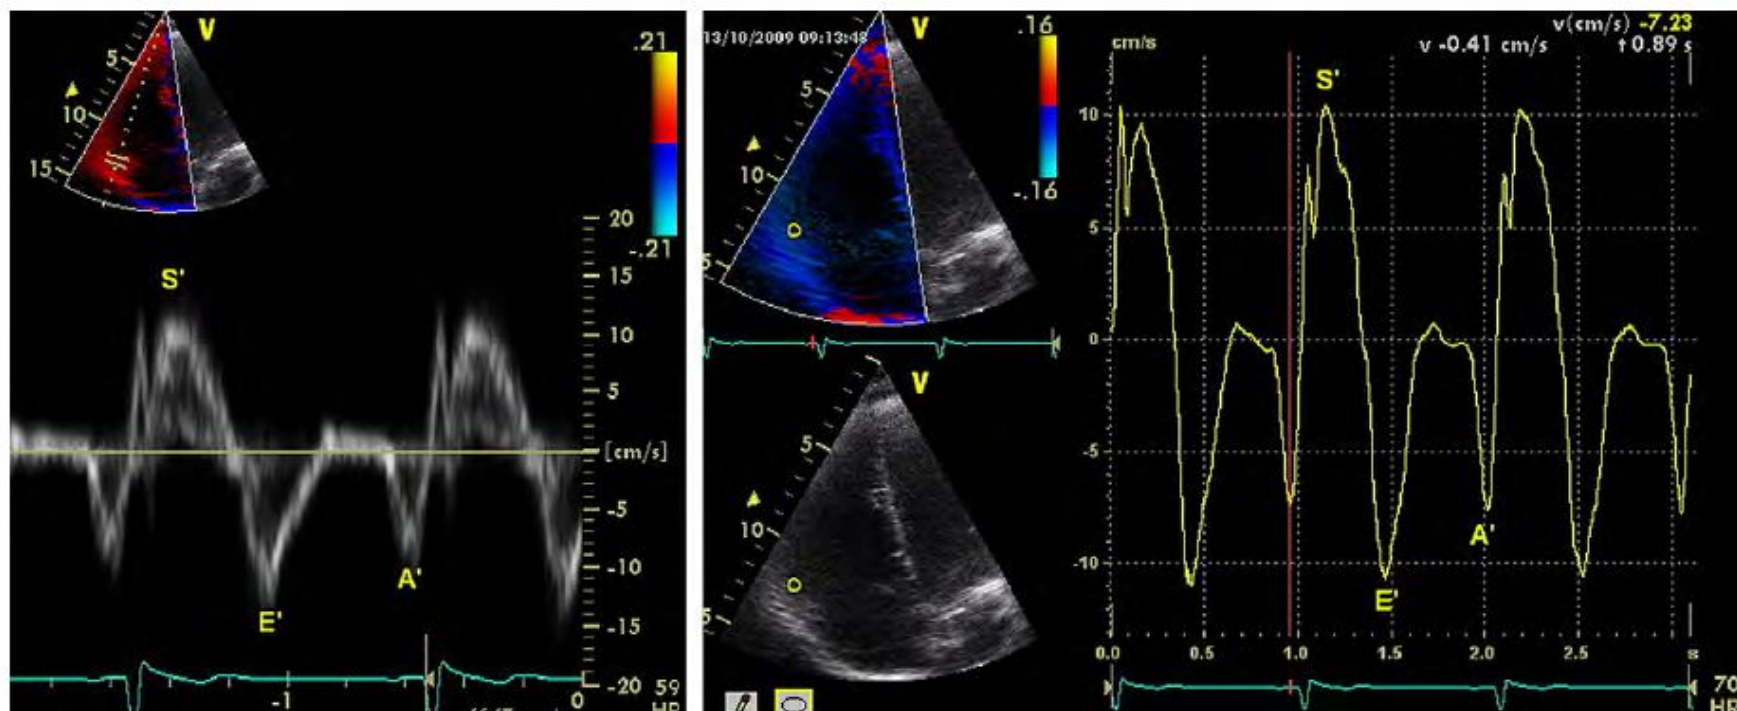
Tissue Doppler of the tricuspid annulus in a patient with normal right ventricular systolic function: (left) pulsed and (right) color-coded offline analysis.
